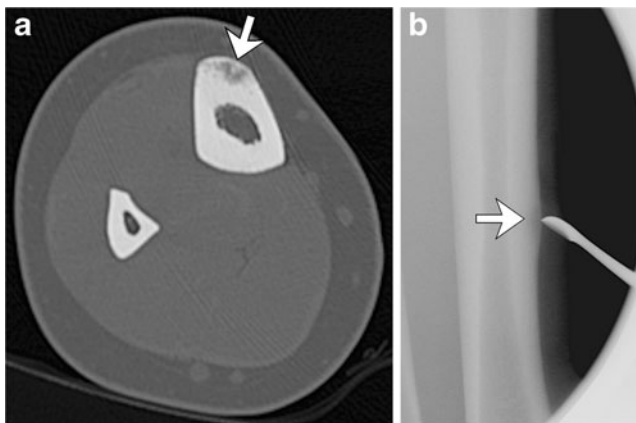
Images in a 14-year-old girl with painful nodular swelling along the right distal anterior tibia. a Axial CT image shows focal rounded lucency with a more central region of sclerosis within the anterior tibial cortex (*arrow*), suggestive of an osteoid osteoma. While the cortex appears focally thickened, there is no overlying fusiform periosteal reaction, as would be expected in an osteoid osteoma. A biopsy was performed. b Lateral radiograph during biopsy demonstrates rounded intracortical osteolysis (*arrow*) with thickening of the anterior tibial cortex. Biopsy confirmed osteofibrous dysplasia
